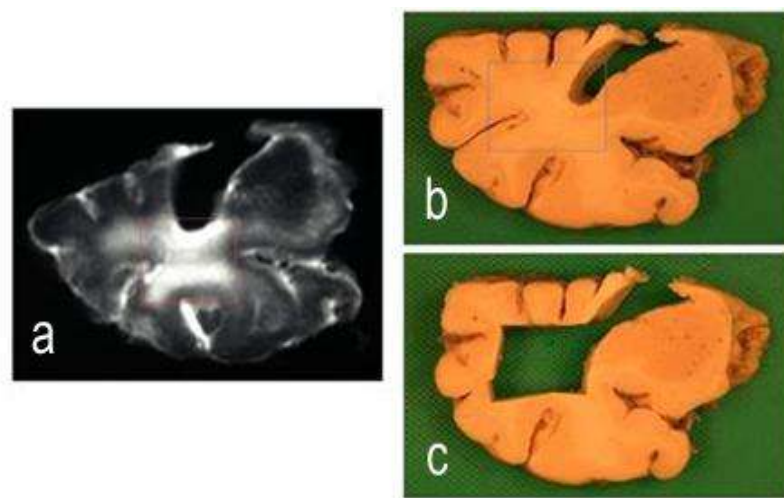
WML sampling. (a) Allocation of WML in the assistance of post-mortem MRI scan. (b,c) Retrieving WML to create a tissue block for further studies
